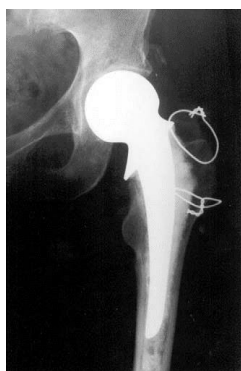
Radiograph of a bipolar Prosthesis.
